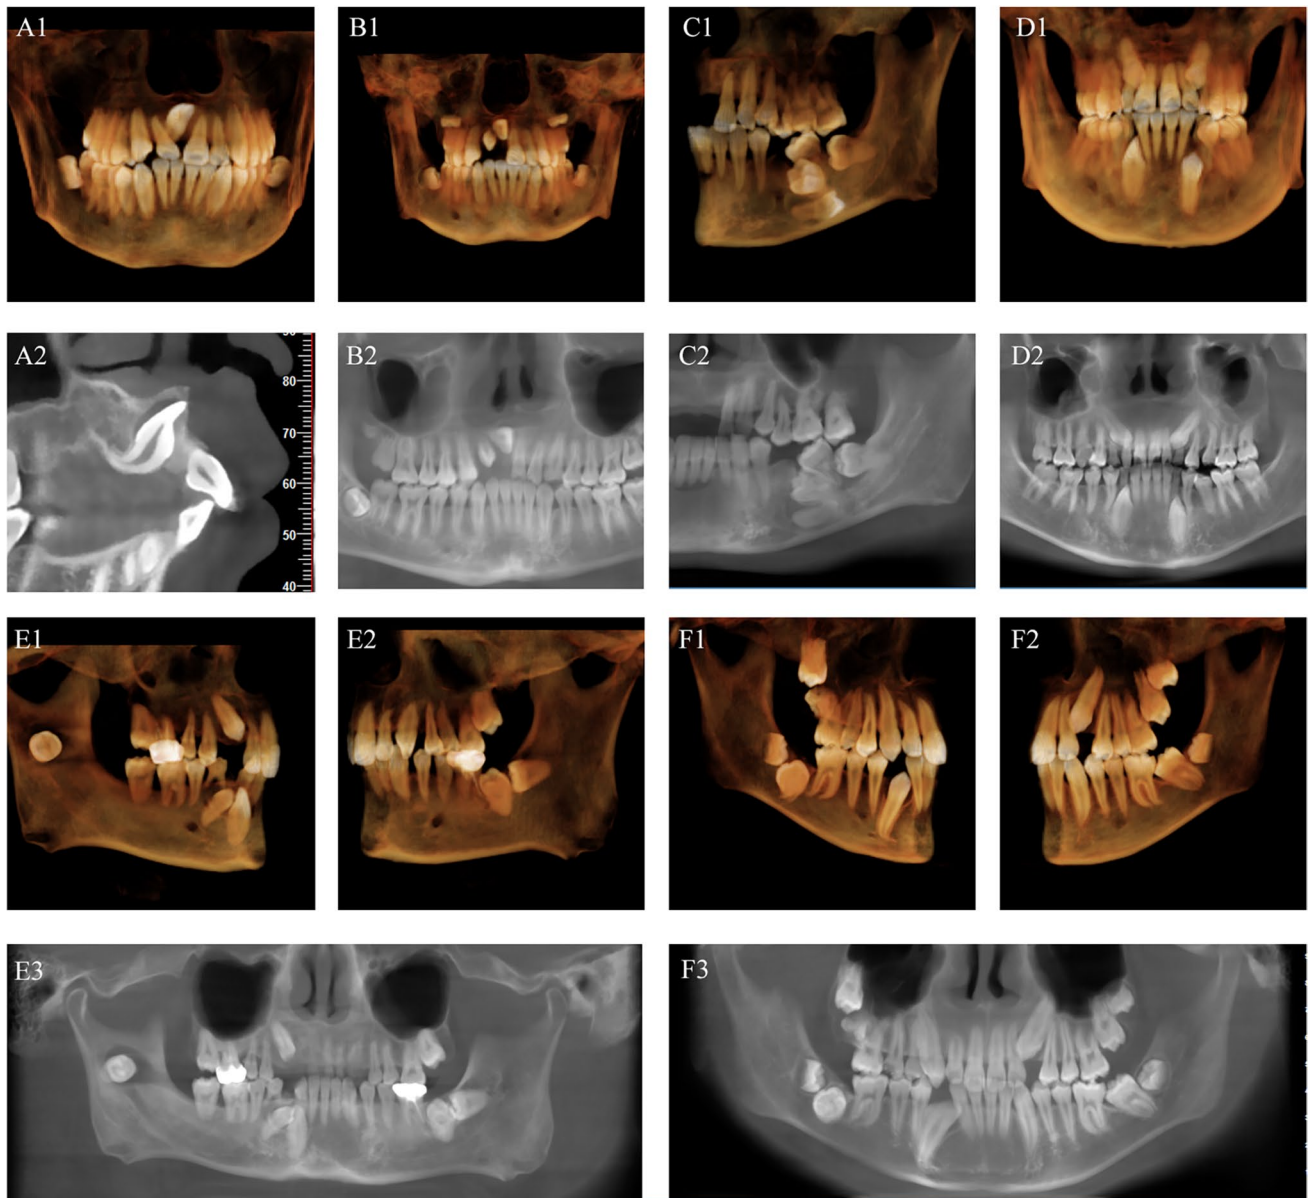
Representative CBCT images exhibiting different numbers of ITEM3. A1-A2: 1 ITEM3; B1-B2: 2 ITEM3s; C1-C2: 3 ITEM3s; D1-D2: 4 ITEM3s; E1-E3: 5 ITEM3s; F1-F3: 6 ITEM3s
